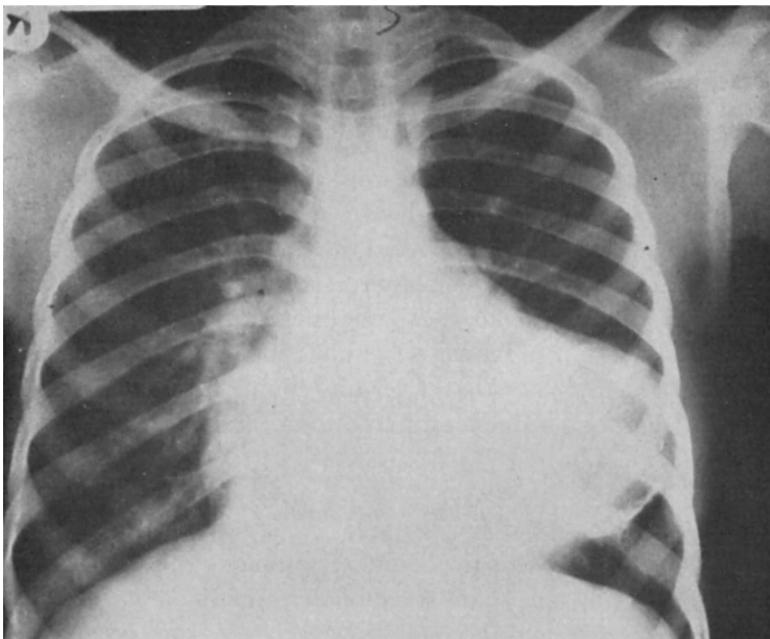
Radiograph showing a calcified left ventricular aneurysm.
